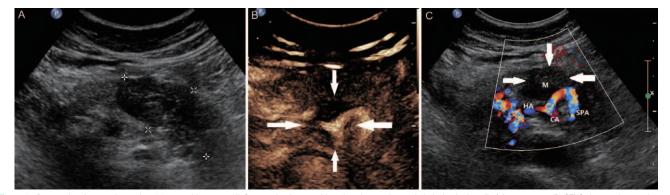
Pancreatic adenocarcinoma in a 60-year-old woman. (A) Gray-scale ultrasound imaging shows a hypoechoic lesion in the tail of the pancreas. (B) CEUS shows a hypo-enhanced area on the left part of the lesion at 85 s (arrows). (C) According to CEUS, a definite diseased area in color (arrows) was determined by Doppler US imaging. Biopsy of the area revealed pancreatic adenocarcinoma. CA: Coeliac artery; CEUS: Contrast-enhanced ultrasound; HA: Hepatic artery; M: Mass; SA: Splenic artery.
